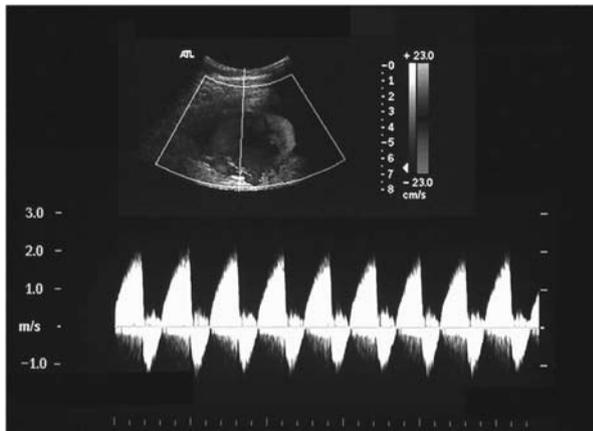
Duplex ultrasound scan of left posterior tibial artery showing a cystic mass with “to-and-fro” waveform highly suggestive of pseudoaneurysm.
